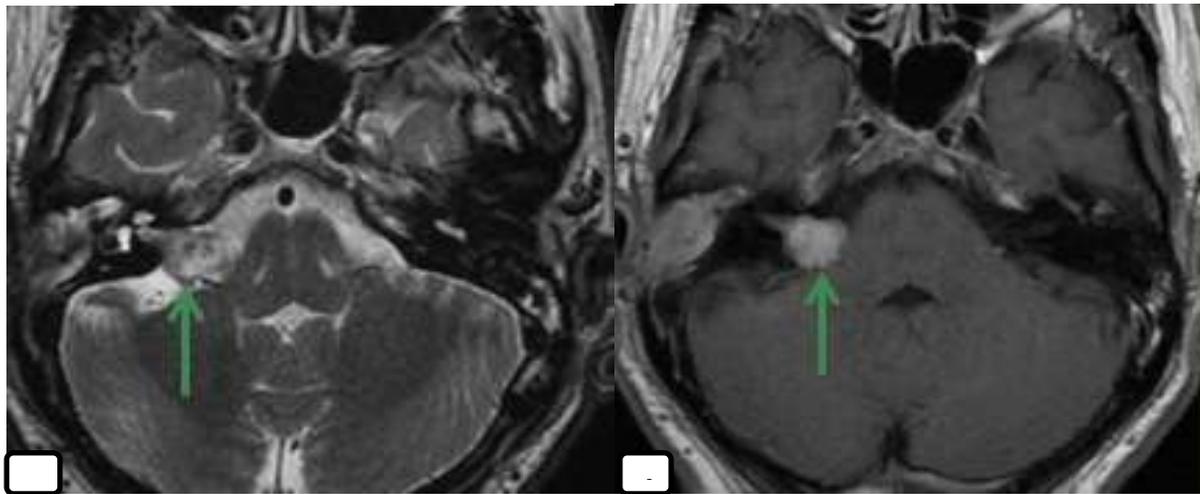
MRI in axial section in T2 sequence (a) and in axial section in injected T1 sequence(b): Extra-axial process at the level of the right internal auditory canal hyperintense in T2 intensely enhanced after contrast. Note the "ice horn" sign (arrow) → Vestibular Schwannoma
